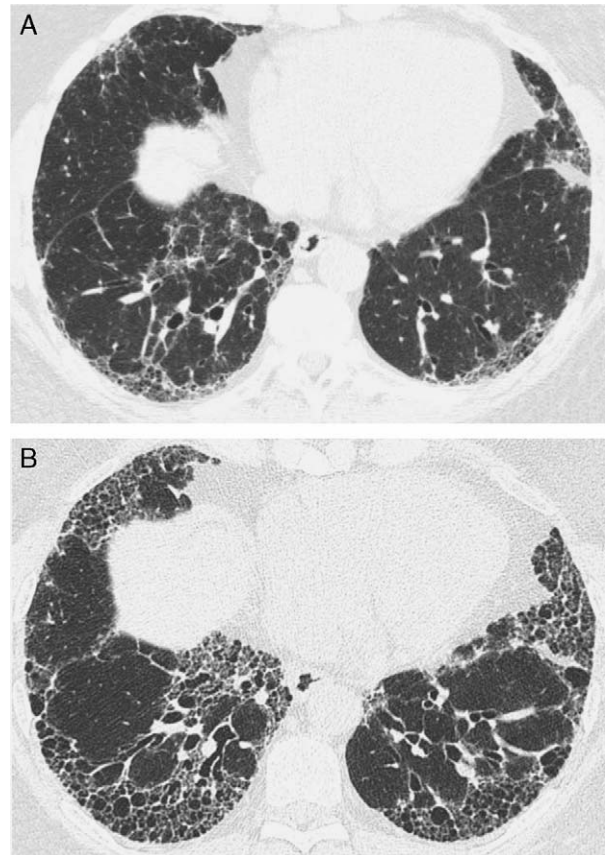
Progression of usual interstitial pneumonia on follow-up. A, HRCT image at the level of the lower lung zones shows mild peripheral reticulation with associated traction bronchiolectasis and ground-glass opacities. B, HRCT image performed 3 years later shows marked increase in the extent of reticulation and development of subpleural honeycombing.
